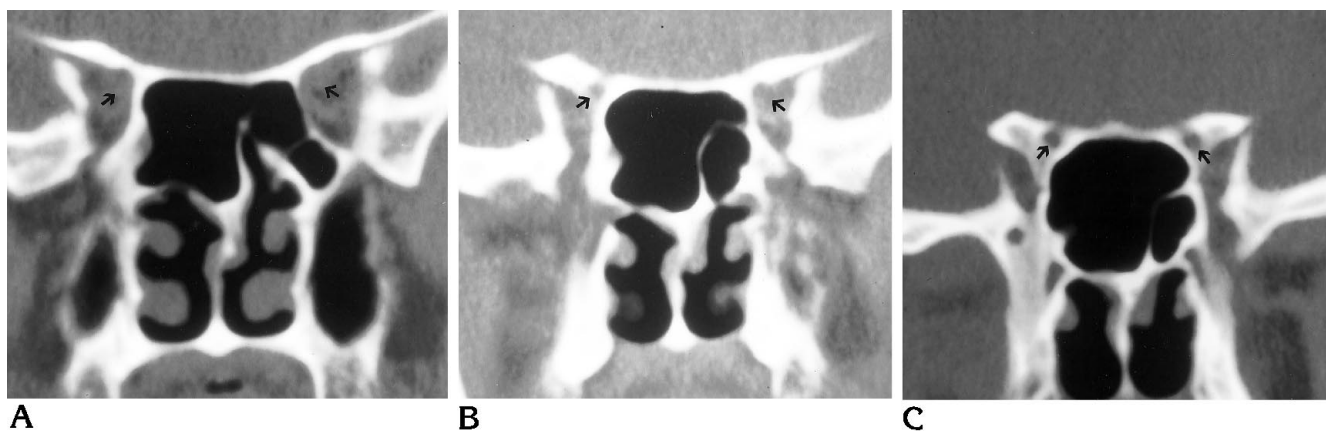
Type 1 optic nerve. Coronal CT scans from anterior (A) to posterior (C) reveal the position of the optic nerve (arrows in A). The optic canal (arrows in B and C) is adjacent to the sphenoidal sinus but does not indent the wall of the sinus.
